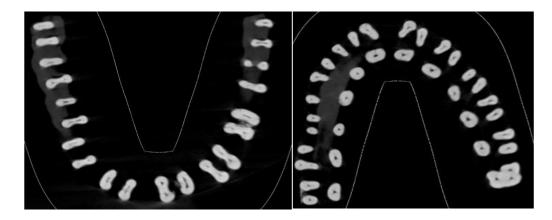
Corona view of the images obtained after scanning of the mounted teeth on the CBCT scanner
